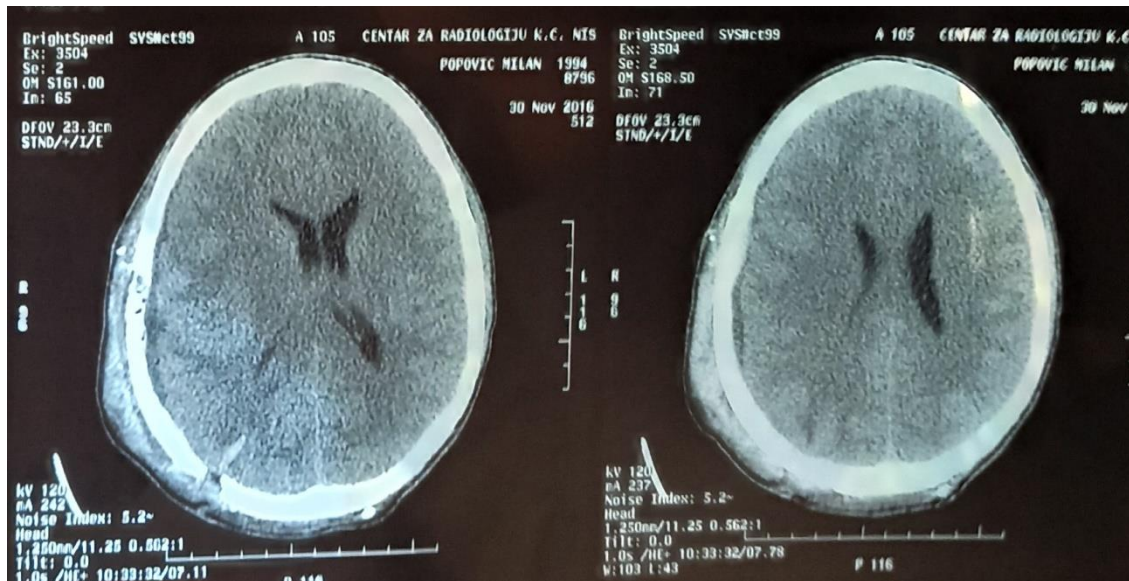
Control CT of the brain after evacuation of epidural hematoma
